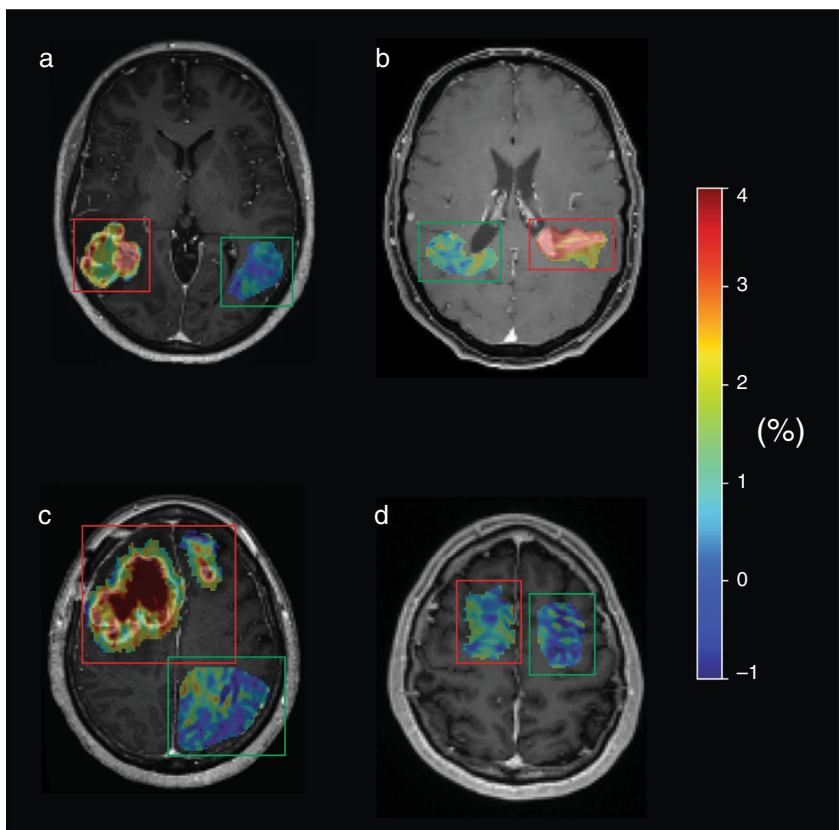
Single transversal APT-CEST slices of four different glioblastoma patients. APT_{CEST} value in color scale projected on the post-contrast T1-weighted image, within the tumor ROI only. Red and green boxes are positioned around the tumor and contralateral ROIs, respectively. Note the heterogeneous hyperintensity in the tumorous regions that show hyperintensity on the contrast-enhanced T1-weighted image when compared to the contralateral region (a–c). (d) The APT-CEST value of a non-enhancing glioblastoma. APT = amide proton transfer; CEST = chemical exchange saturation transfer; ROI = region of interest.
